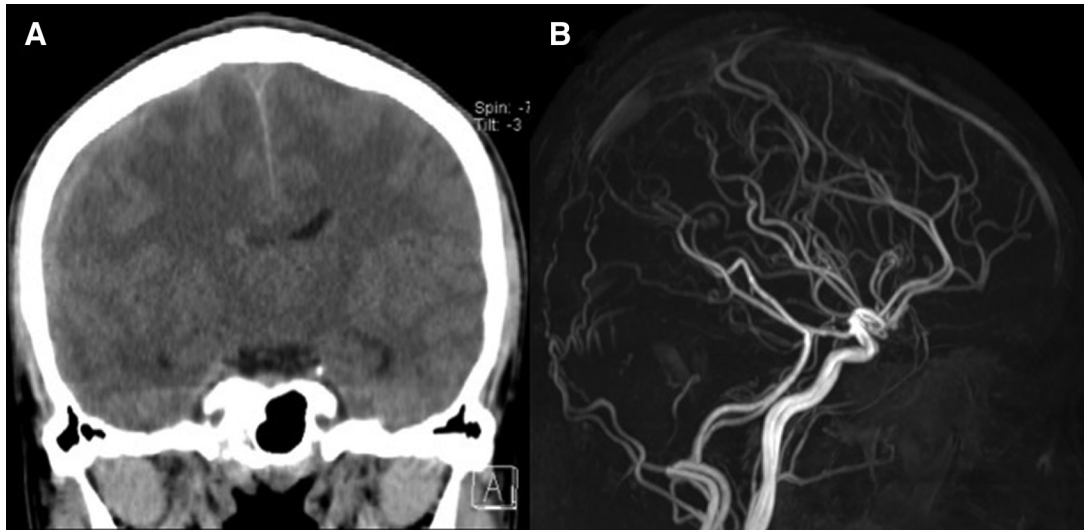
(A) Coronal CT shows a thin acute SDH on the right cerebral hemisphere with a mild midline shift. (B) MRA shows the SSS and cortical vein. SDH: subdural hematoma; SSS: superior sagittal sinus
